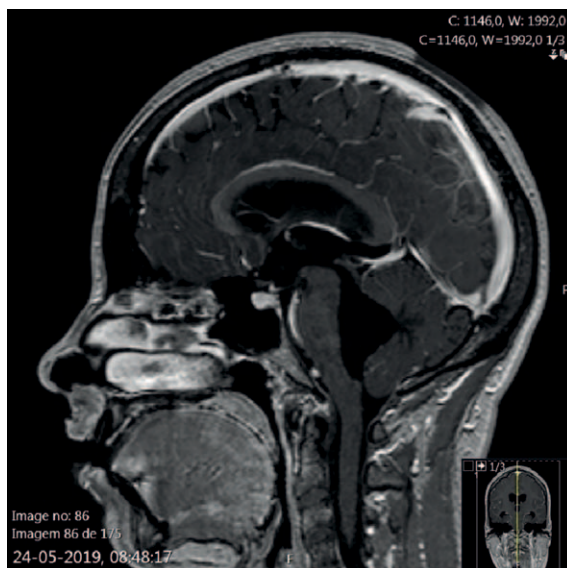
T1 sequence, Sagittal cut MRI with gadolinium. Tetraventricular hydrocephalus. A cystic formation on fourth ventricle with mass effect over brainstem anteriorly and over cerebellar vermis posteriorly. No abnormal gadolinium enhancement.
